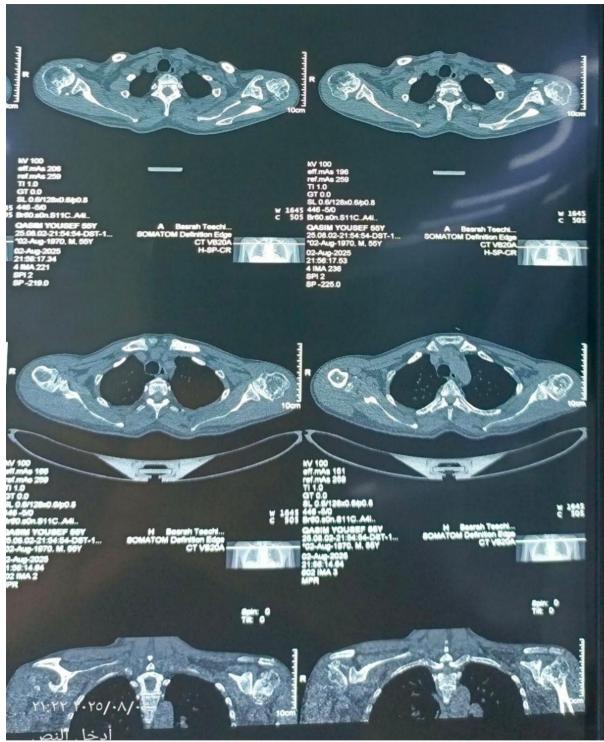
CT scan (coronal and Axial Non-contrast View) of 55 years male shows areas of sclerosis and irregularity in the humeral head with patchy mottled density and evidence of subchondral collapse, the glenohumeral joint space is relatively preserved.
